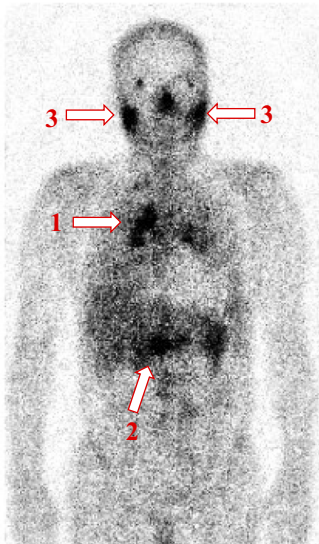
Gallium 67 scintigraphy. Gallium 67 scintigraphy showed an increased uptake in the pulmonary hilar lymph nodes (arrow 1), abdominal lymph nodes (arrow 2), and parotid gland (arrow 3).
